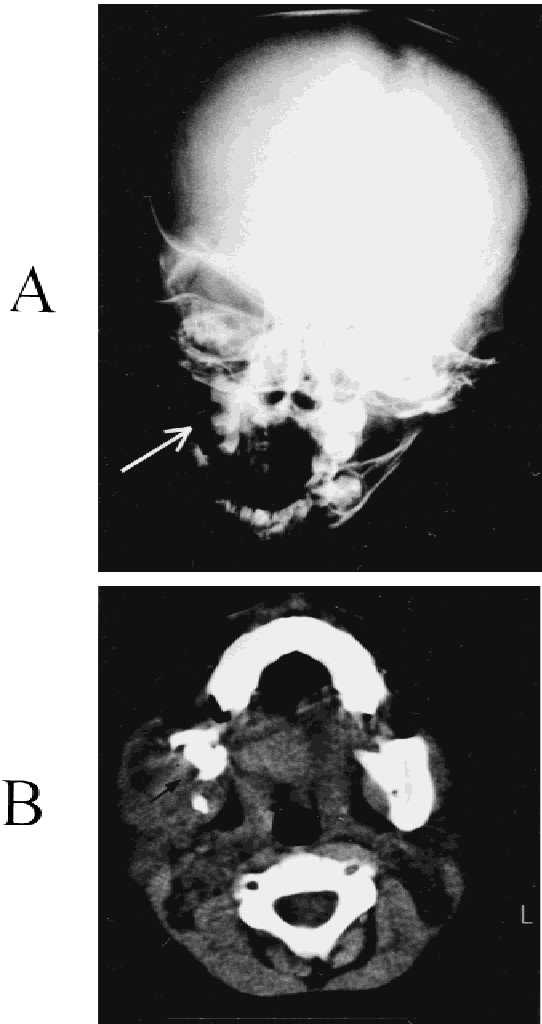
(A) Frontal view of the skull by X-ray radiogram revealed osteolytic lesion of the right mandible (arrow). (B) CT image showed destruction of the right mandible and filling of the soft tissue mass (arrow).
